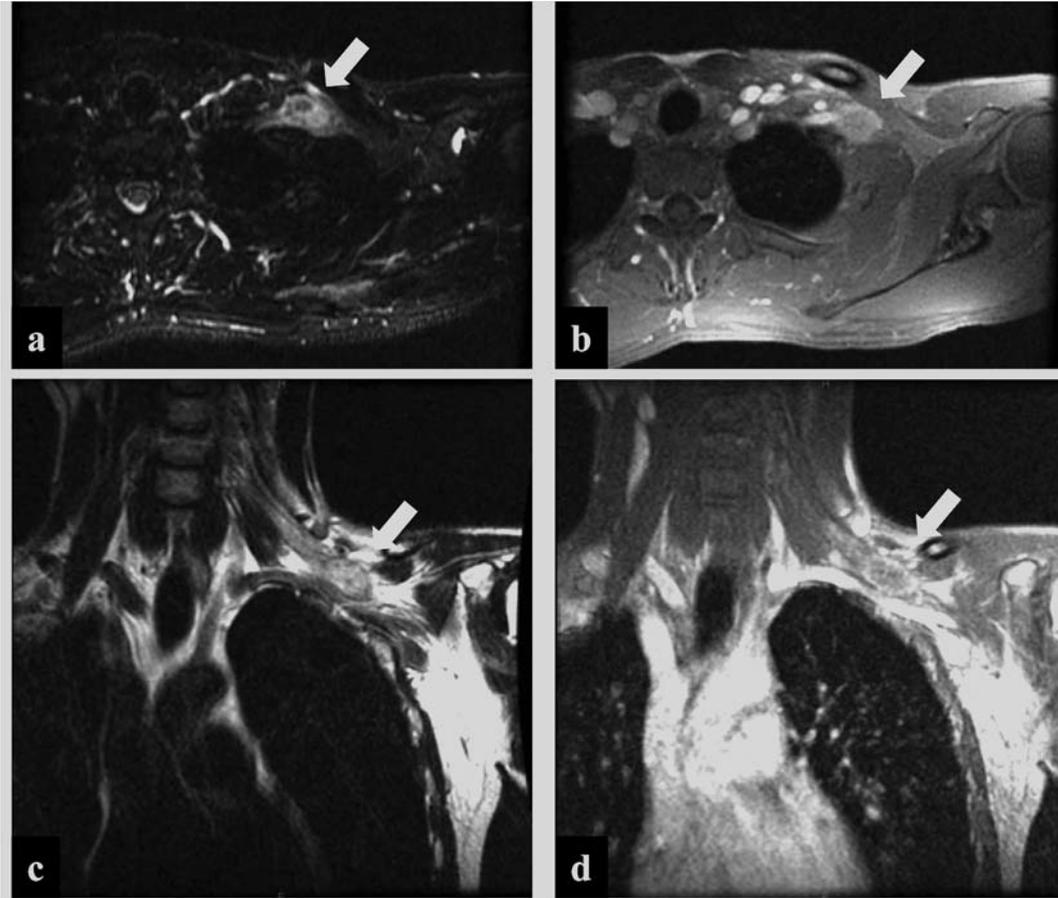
Magnetic resonance imaging. a: Axial T2-weighted image shows the tumor at the brachial plexus (arrow). b: Gadolinium-enhanced axial image shows ring enhancement (arrow). c: Coronal T2-weighted image shows the tumor in the left brachial plexus (arrow). d: Gadolinium-enhanced coronal image shows ring enhancement (arrow).
